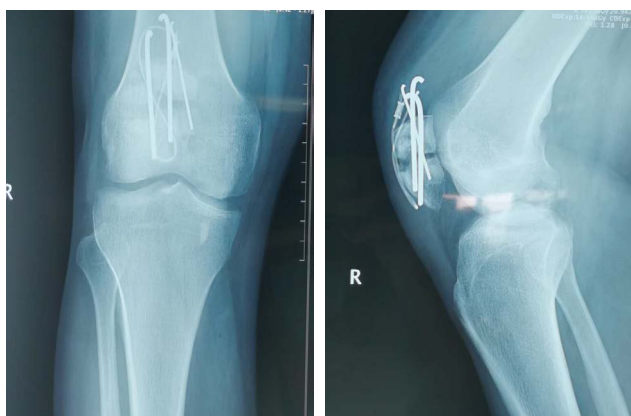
Preoperative radiograph of nonunion of patella fracture.
